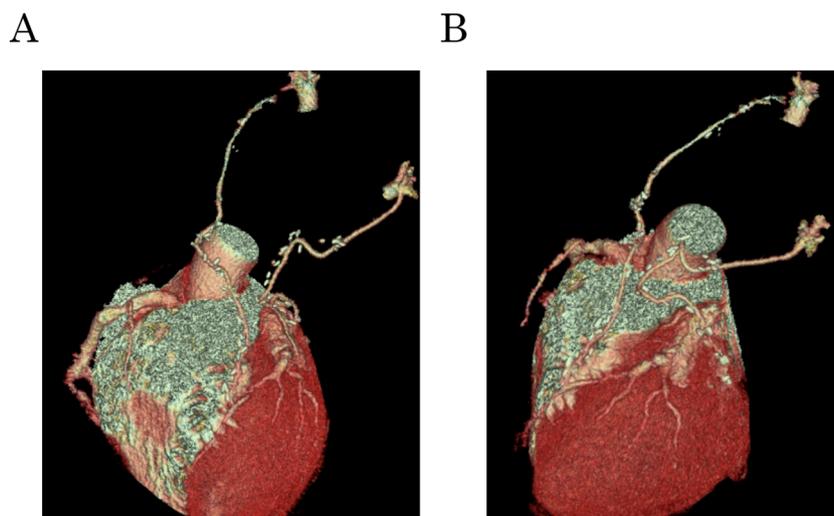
Volume-rendered images of the heart by cardiac CT after the operation
